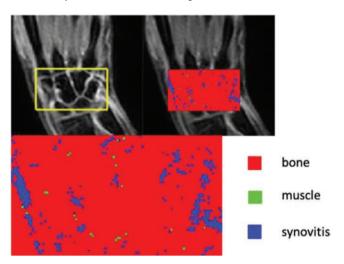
Software performance on contrast enhanced dynamic MRI of the wrist
